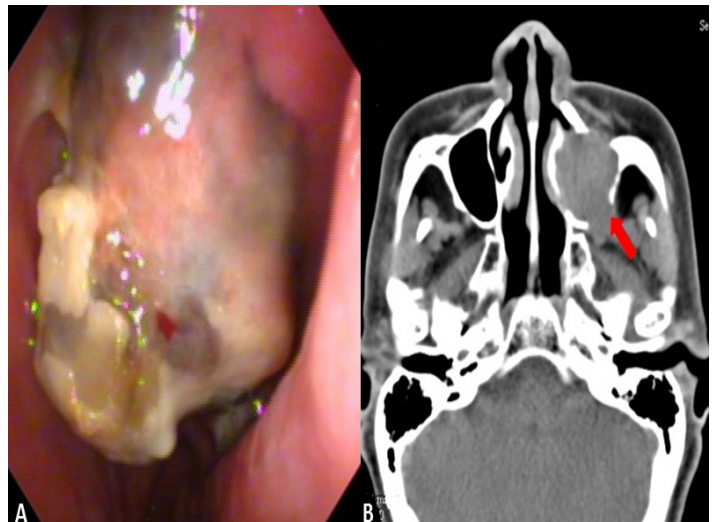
A: Friable, easy touch bleeding mass locates at left middle meatus. B: Computed tomography exhibits the lesion making opacities of left maxillary sinus with bony destruction of posterior antrum (red arrow)
